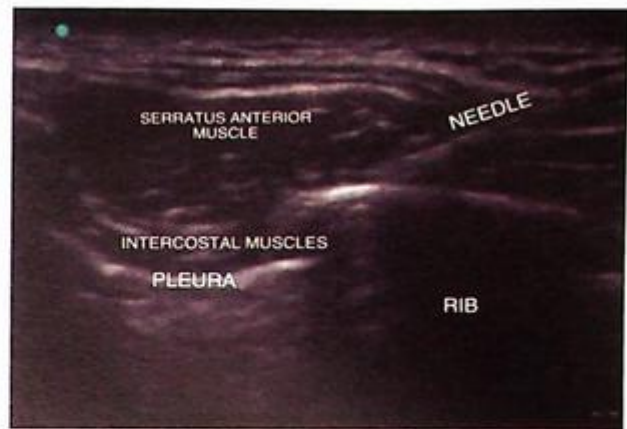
Ultrasound image of the serratus anterior block with the needle deep to the serratus anterior muscle but superficial to the intercostal muscles. The injection of LA is between the serratus anterior and intercostal muscles. Note that the pleura is always visualized when performing the block to avoid pneumothorax or injury to the lung.
